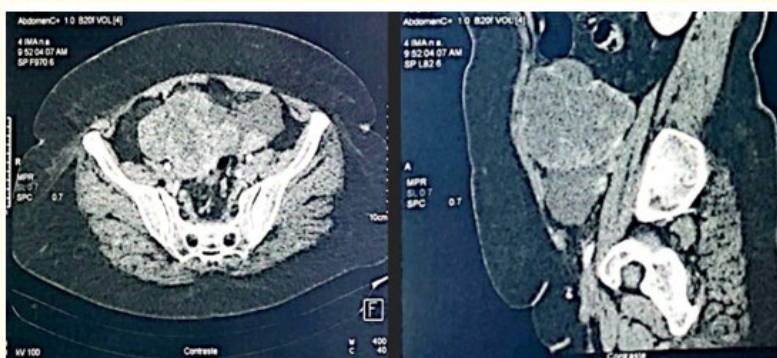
CT scans identifying right adnexal heterogenous mass with contrast uptake.
